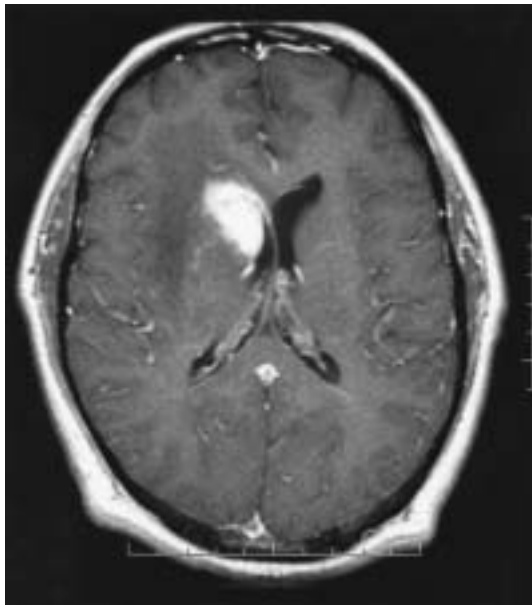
Case 1. Magnetic resonance image of the brain showing Langerhans cell histiocytosis lesion of the central nervous system.
